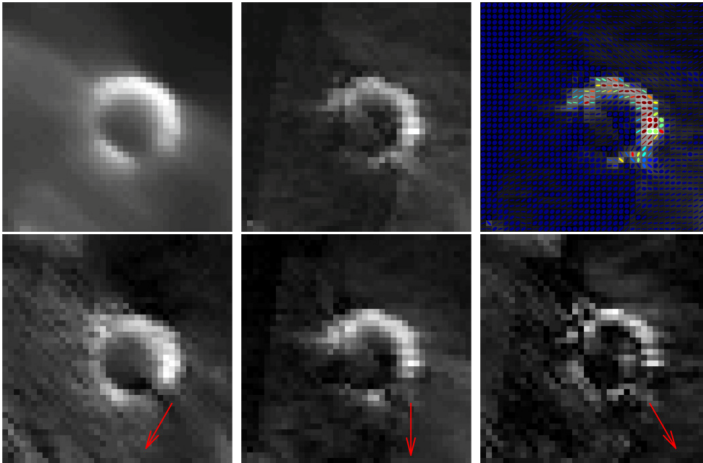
Top: Reconstruction Comparison. (left) Conventional reconstruction from arbitrarily sampled vascular ultrasound data obtained by backward-interpolation using median compounding. (middle) Absolute value of the trace of the reconstructed tensors. (right) Tensors visualized as colored ellipses. Note that the trace image nicely resembles the high intensities of the boundary and that tensors align with the global orientation of the imaged structures. Bottom: Directionality of Tensors. Reconstructed tensors allow for a reconstruction of directional B-Mode ultrasound information in arbitrary directions, as indicated by red arrows.
